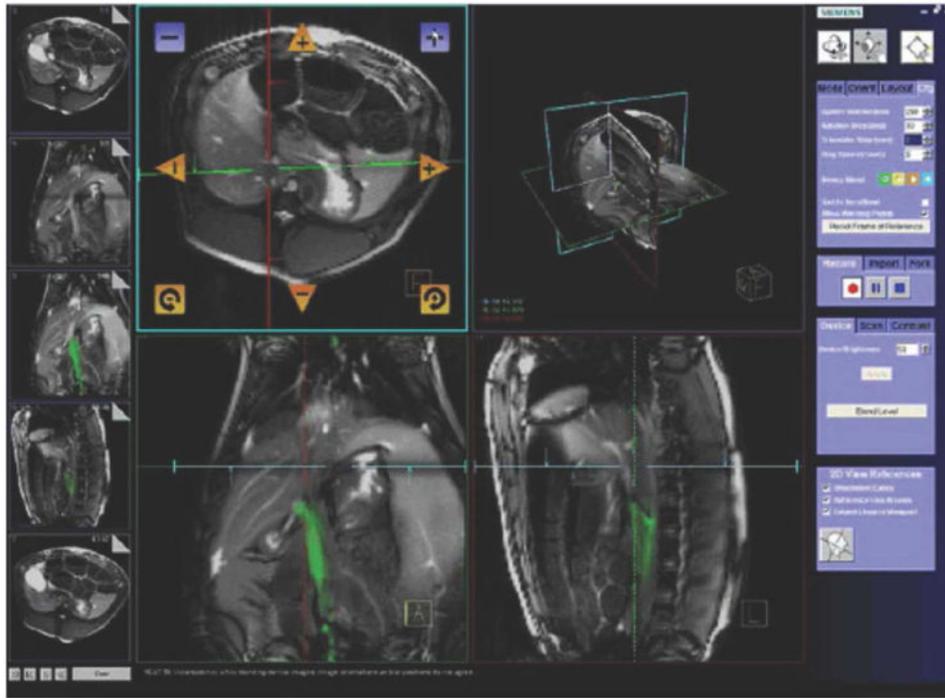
Interactive Front End (Siemens) user interface for MRI-guided navigation. (From Saikus CE, Lederman RJ. Interventional cardiovascular magnetic resonance imaging: a new opportunity for image-guided interventions. *JACC Cardiovascular imaging* 2009;2(11): 1321-1331, with permission.)
